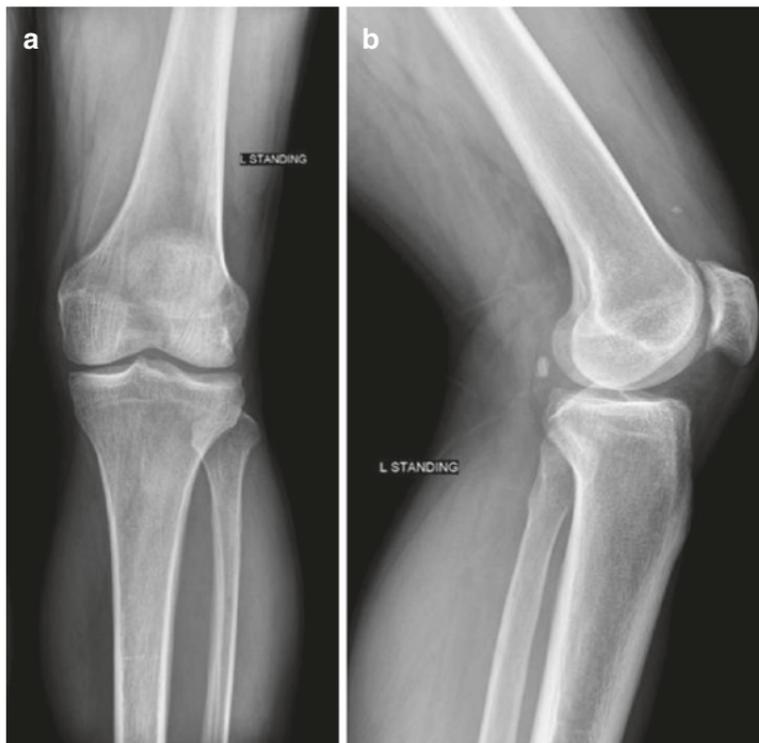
Preoperative plan standing AP (a) and lateral (b) radiography
